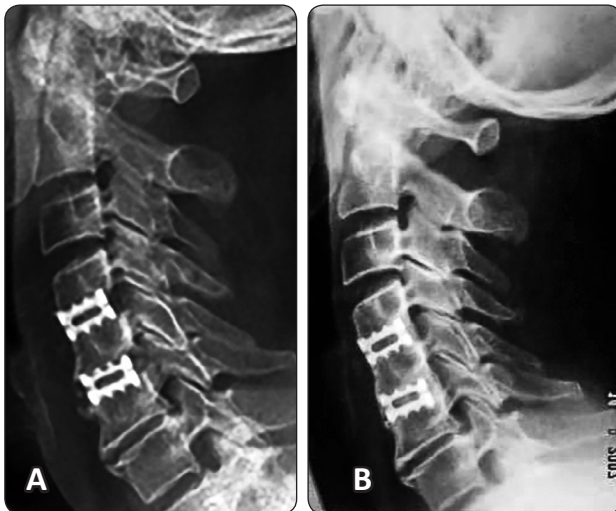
(A) Postoperative and (B) End follow up (15 months) lateral X-ray of the cervical spine after ACDF C4-C6 showing no cage subsidence.
